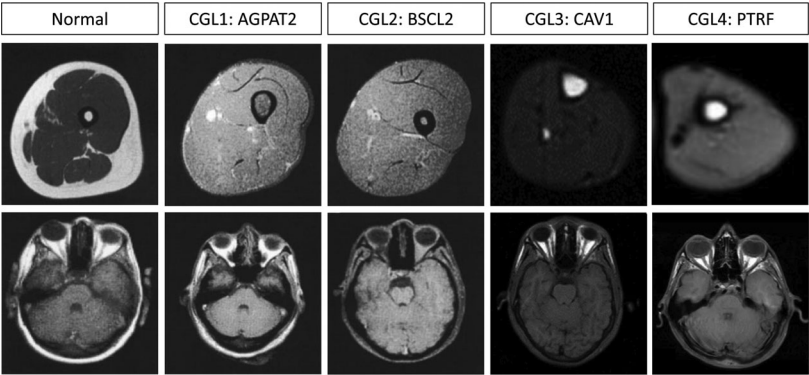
T1-weighted MRI images of WAT and MAT in CGL. Transverse T1-weighted MRI cross-sections of the limb (top row) and skull at the level of the orbits (bottom row) in patients with CGL as compared to control. In the limb of a normal control a thick layer of subcutaneous adipose tissue (white) is present around a core of muscle (gray). In the center is bone (black) that is filled with marrow adipose tissue (white). Both subcutaneous and marrow adipose tissue are absent in CGL1 and CGL2. In CGL3 and CGL4, subcutaneous fat is lost while marrow fat is maintained. In the cranial section, a layer of mechanical white adipose tissue is present around the skull and behind the orbits. Both mechanical depots are maintained in CGL1, both are lost in CGL2, and the fat behind the orbits but not around the skull is present in CGL3 and CGL4. Images for normal (age 30, female, femur), CGL1 (age 31, female, femur), and CGL2 (age 11, female, femur) from Ref. 28; CGL3 (age 19, female, tibia) from Ref. 32; and CGL4 (Age 14, male, humerus) from Ref. 50.
